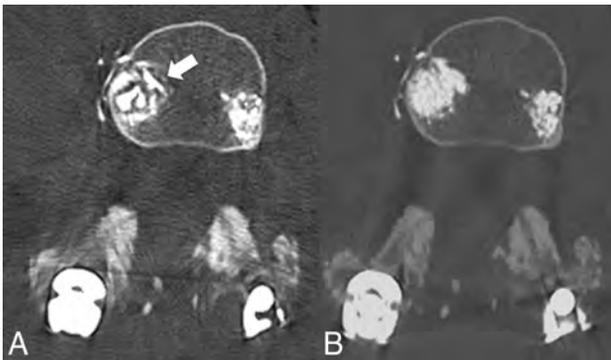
A, Axial CT image with MAR applied demonstrating an irregular fragmented appearance of bone cement with indistinct margins (*white arrow*). B, Non-MAR counterpart image with normal appearance of bone cement with accurate representation of vertebral filling.
